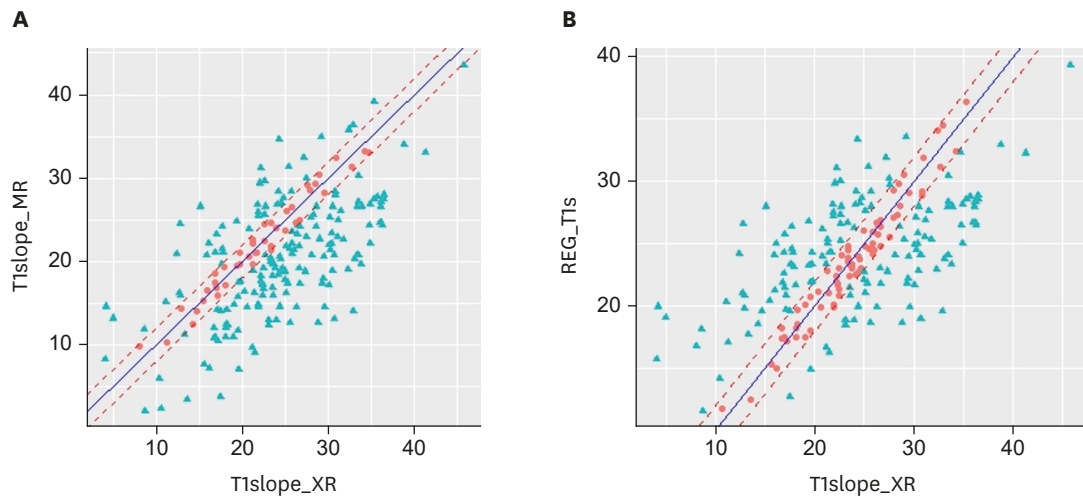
Replacement ratio for T1s. (A) Blue line indicates regression line between MR and XR, and the red dotted line indicates MR value equal to $\text{XR} \pm 2^\circ$. (B) Blue line indicates regression line between MR-E and XR, and the red dotted line indicates MR-E value equal to $\text{XR} \pm 2^\circ$. MR: magnetic resonance, MR-E: magnetic resonance-expected value, T1s: T1 slope, XR: X-ray.
